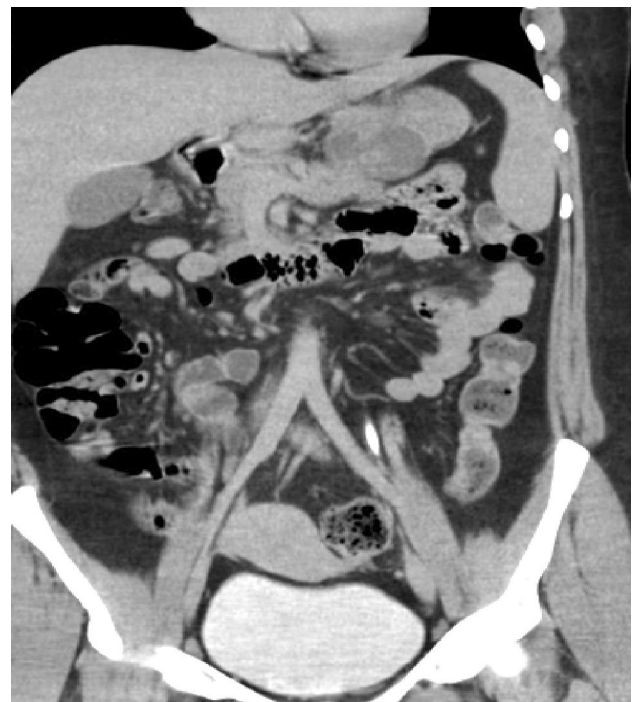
Coronal CT scan showing cystic lesion involving greater curvature.
